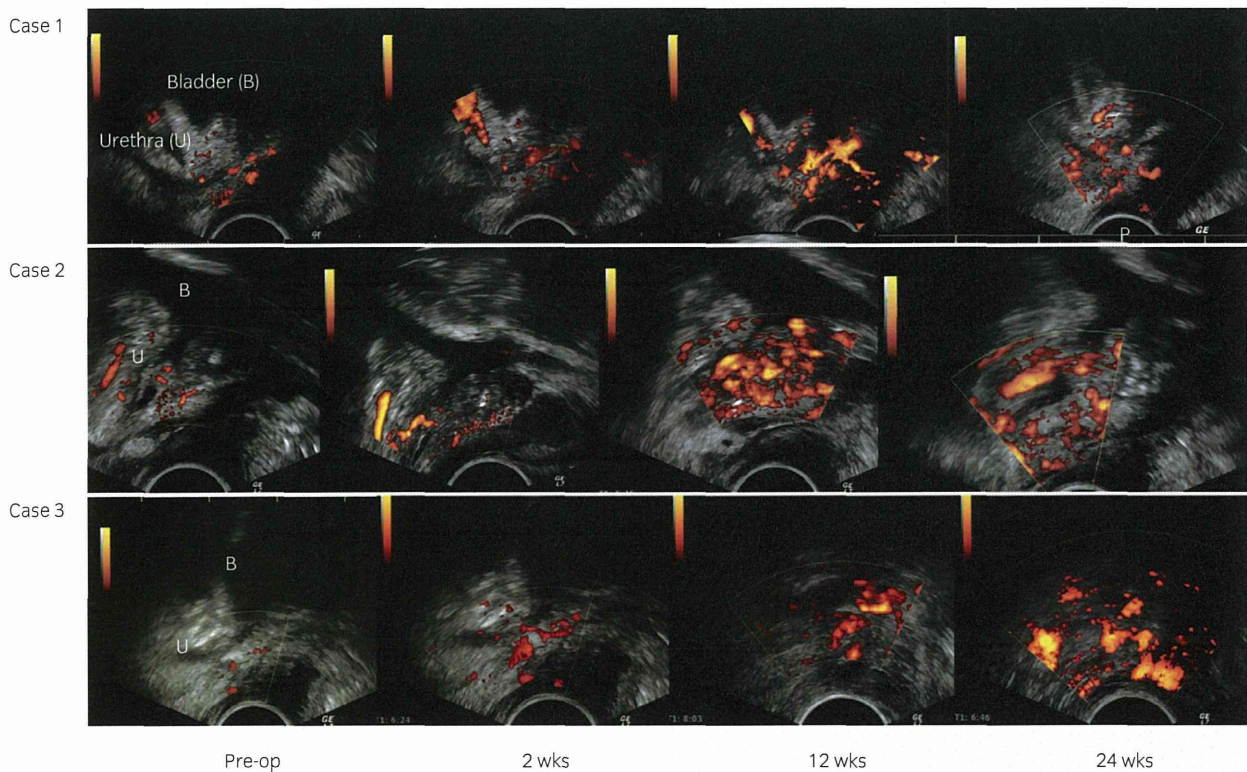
Contrast-enhanced transrectal ultrasonography to assess the blood flow of the periurethral area after ADRC injection. The bladder and urethra was visualized as a sagittal section. The blood flow around the injected area visualized as orange color was progressively increased after the injection of ADRC up to 6 months in case 1, 2 and 3, showing a progressive increase of blood flow at the injection site.
